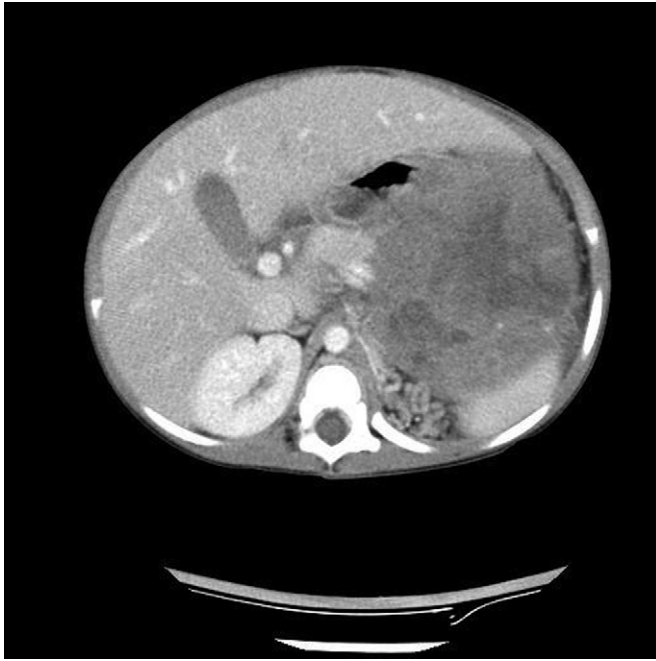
A computed tomography (CT) scan of a unilateral Wilms' tumor.
